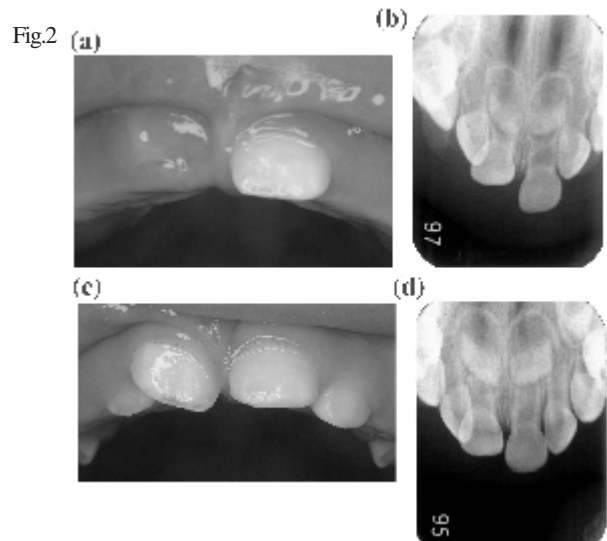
Initial oral color photo (a) and radiograph (b) (1y2m, female) An oral color photo at 3 months after the injury (c) A radiograph at 6 months after the injury (d)
